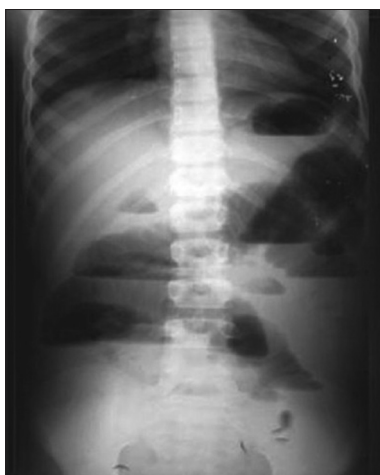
Plain X-ray abdomen erect posterior-anterior view shows multiple air-fluid levels with features of small bowel obstruction. No free air under the diaphragm. Fat plane psoas shadow are normal
